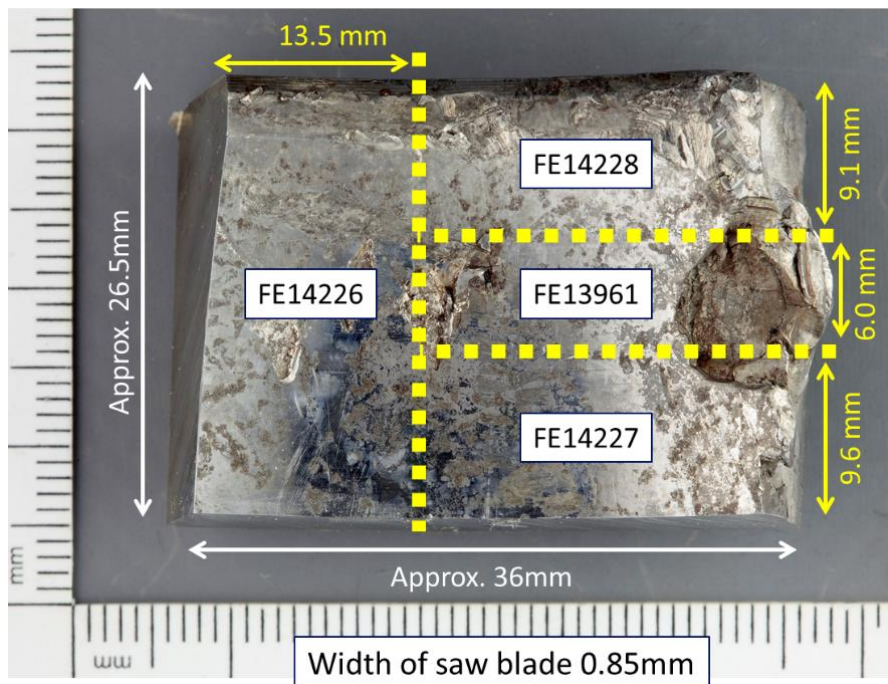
Cutting lay out based on CT-scan results (see Figure 37). FE13961 contains spall three and four, FE14226 contains spall one and two. Photo: AIBN/QinetiQ
